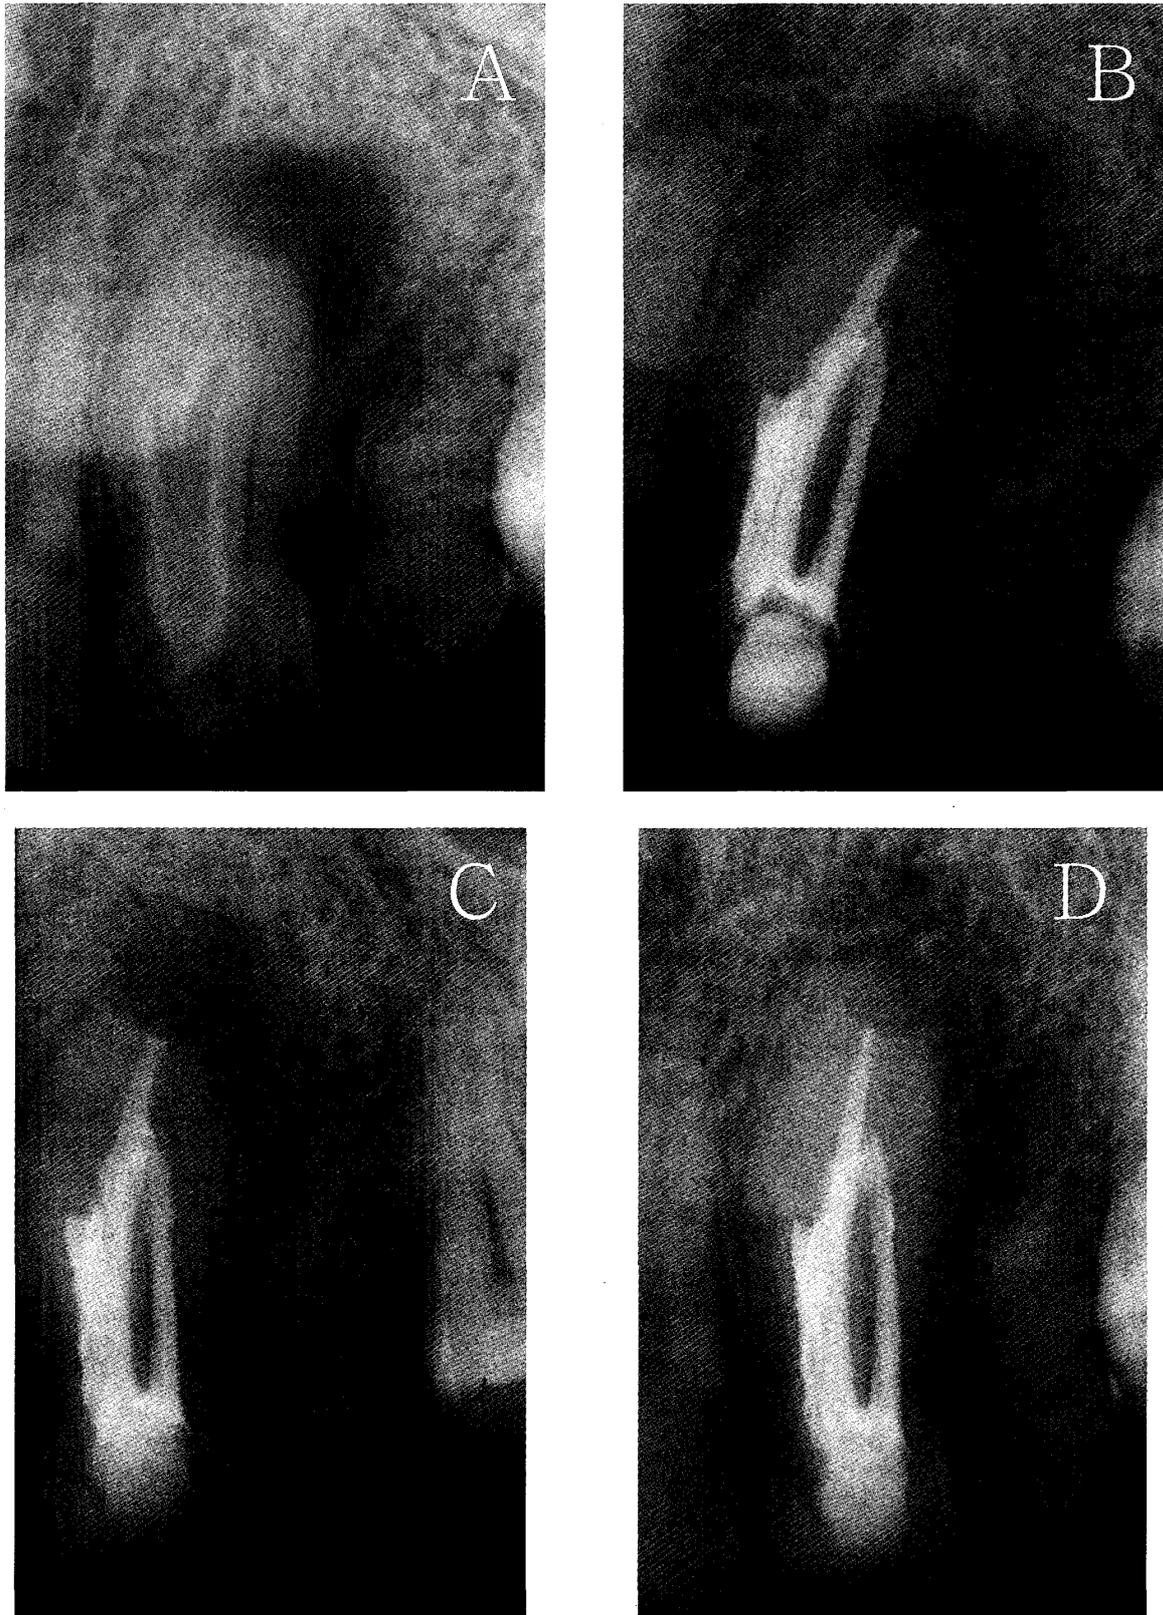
A: Preoperative radiograph showed maxillary left lateral incisor with dens invaginatus and periradicular radiolucency.
